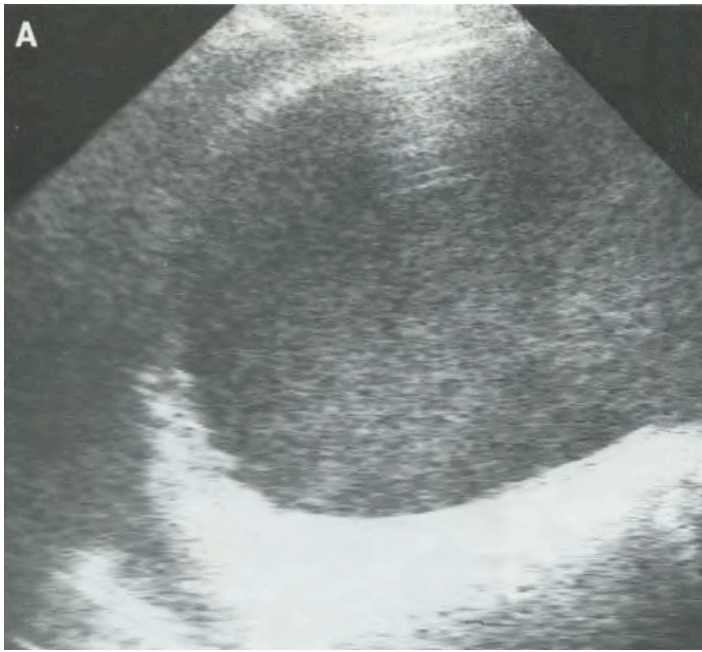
Sagittal ultrasound of the bladder in a patient with pyocystis reveals complex heterogeneous fluid within the urinary bladder. Reprinted with permission, courtesy Elsevier from Tung and Papanicolaou. *J Can Assoc Radiol.* 1990.
